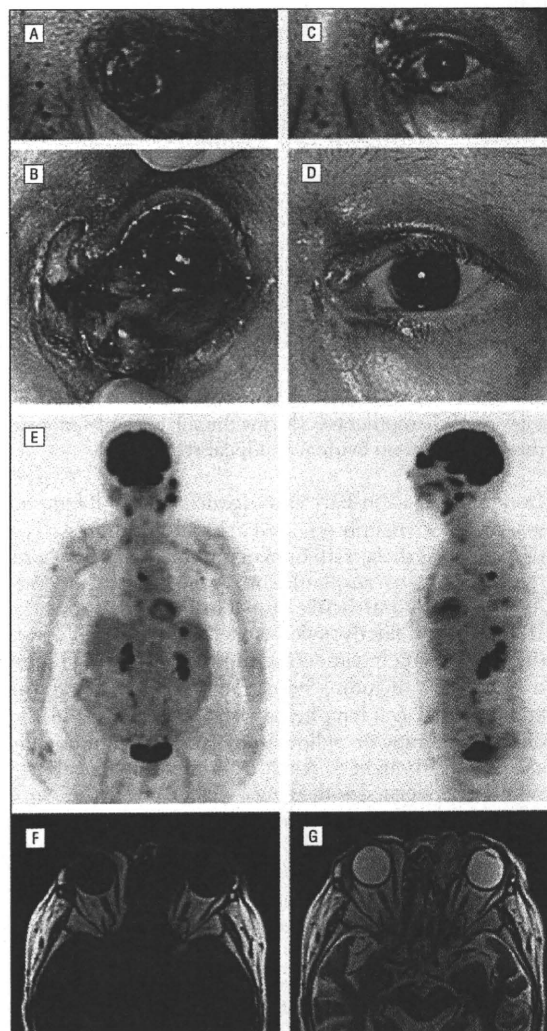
Images from a patient with Epstein-Barr virus-positive diffuse large B-cell lymphoma of the elderly. A and B, Before starting chemotherapy. C and D, After completion of chemotherapy. E, Positron emission tomography confirms marked left orbital uptake. There is also uptake in the spleen, mediastinum, and involved lymph nodes. F and G, Orbital magnetic resonance imaging shows a cystic mass in the left periorbital region that invades the orbit and anterior ethmoid sinus and is accompanied by eyelid ulceration. The mass shows heterogeneous low signal intensity on a T1-weighted axial image (F) and high signal intensity on a T2-weighted axial image (G).
